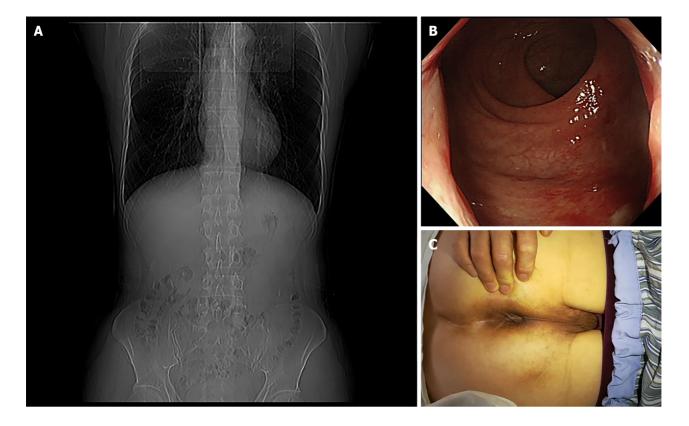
Postoperative evaluation of gastrointestinal foreign body and intestinal lumen status. A: After 3 d of postoperative follow-up, no foreign objects or residues were found on computed tomography scanning; B: 3 d later, a follow-up colonoscopy was performed, and there was no damage to the intestinal cavity and no foreign body residue; C: 3 d after surgery, the symptoms of internal prolapsed hemorrhoids disappeared.
